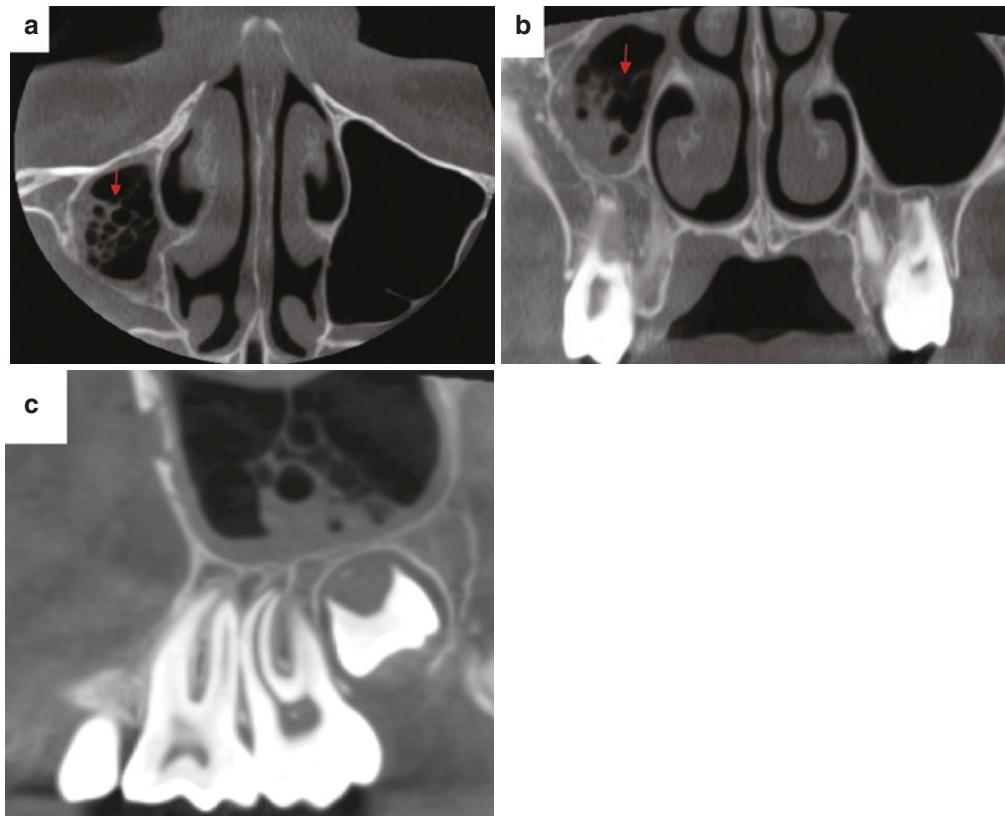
CBCT axial (a), coronal (b), and sagittal (c) images show inflammatory changes in the right maxillary sinus (red arrow). Note the bubbly-appearing (dark) fluid in the right maxillary sinus. No inflammatory changes are
